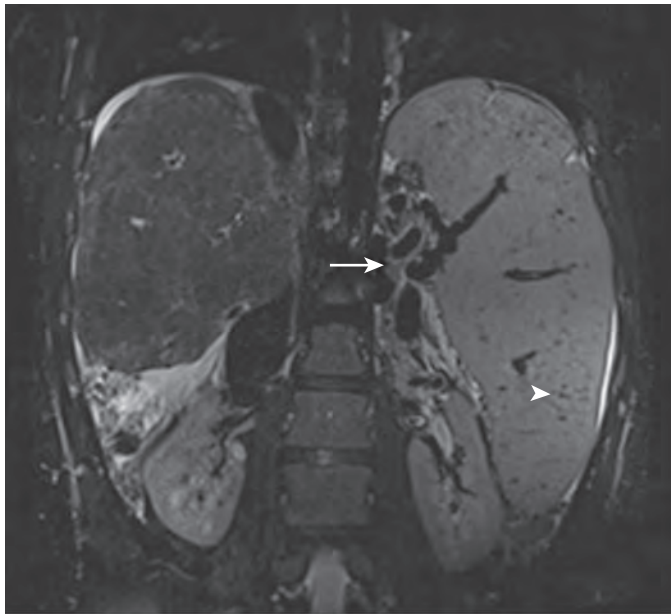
Splenomegaly: MR findings. The spleen is grossly enlarged, extending inferior to the cirrhotic right hepatic lobe. Note the splenic hilar varices (arrow) and punctate hypointense splenic siderotic nodules (arrowhead) on this T2-weighted coronal image.
